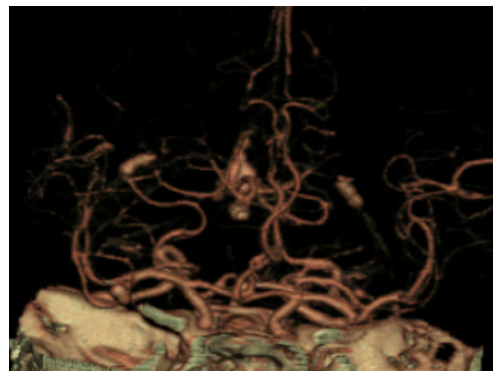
Computed tomography (CT) angiography of the same aneurysm depicted in Figure 2.
